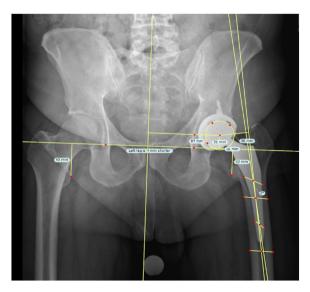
Postoperative AP pelvis radiograph demonstrating the measurement of femoral stem coronal alignment as the angle subtended by the long axis of the femoral component and the anatomical axis of the femur.
